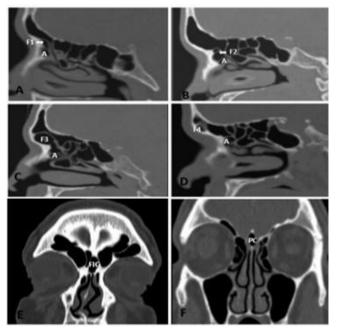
Plain CT of PNS sagittal section*: A) Type I frontal cell(F1); B) Type II frontal cell (F2); C) Type III frontal cell (F3); D) Type IV frontal cell (F4). Agger nasi cell (A); E) Plain CT of PNS coronal section shows Frontal intersinus septal cell (FIC); F) Plain CT of PNS coronal section shows Pneumatized crista galli (PC).
